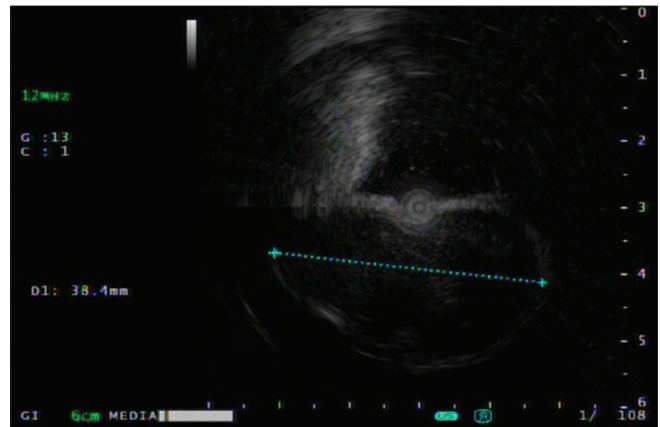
A homogeneous low-echo subepithelial tumor approximately 3.8 cm in size growing from the muscularis propria; diagnosed as a gastrointestinal stromal tumor under endoscopic ultrasonography examination
